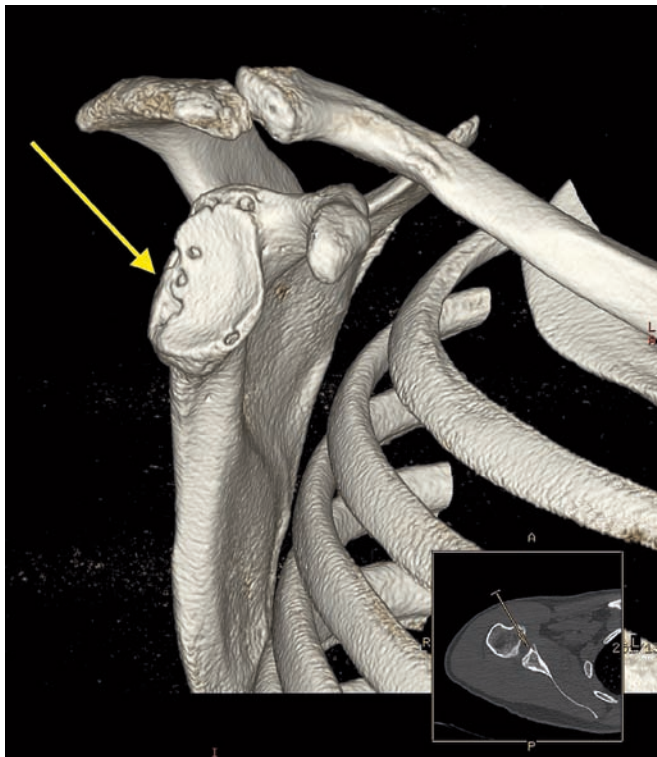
A three-dimensional CT scan showing significant posterior bone loss after 2 failed posterior instability repairs (*yellow arrow*).
